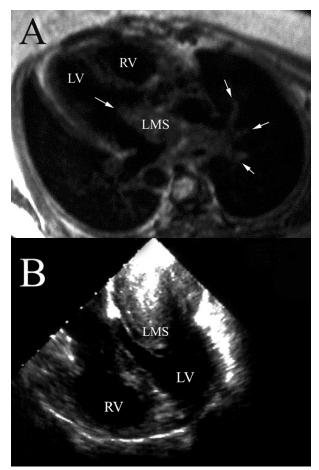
(A) Magnetic resonance image of relapse 2: horizontal plan shows the tumor in the left atrium diffusing into the branches of the pulmonary veins (arrows). LA = left atrium, LMS = leiomyosarcoma, LV = left ventricle, RV = right ventricle. (B) Transesophageal view of relapse 2.
